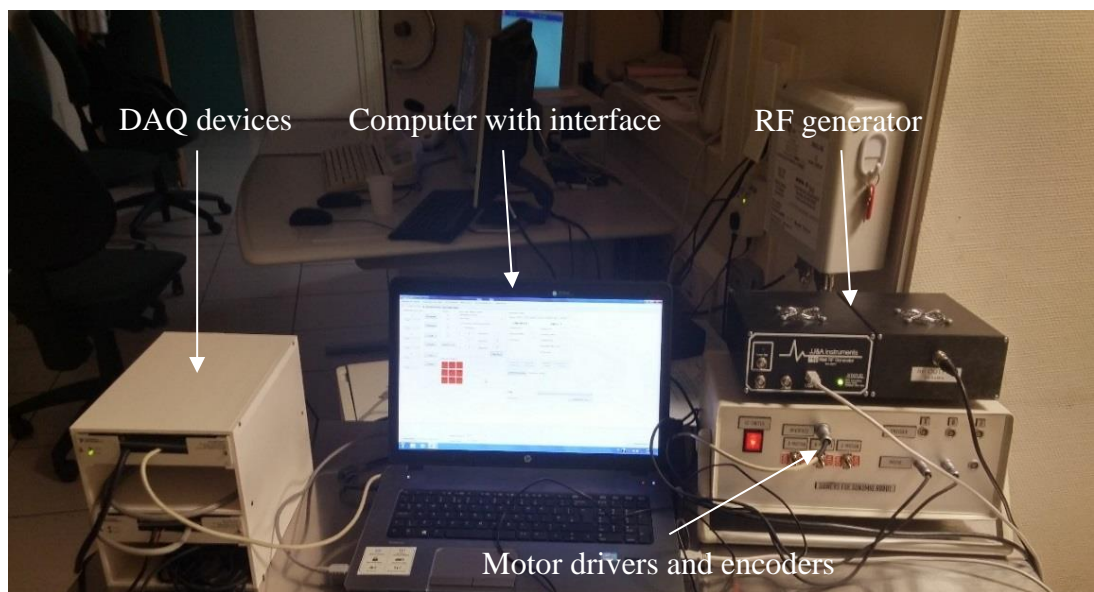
Control station of positioning device and RF power for driving the HIFU transducer under MRI guidance.
